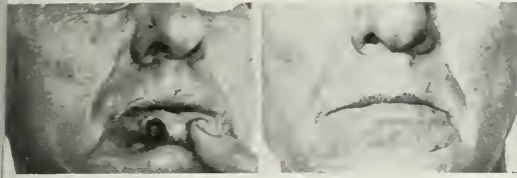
SMALL EPITHELIOMA OF THE LIP. SHOWING THE END RESULT AFTER ELECTRO-COAGULATION AND ROENTGEN RAY TREATMENT.
